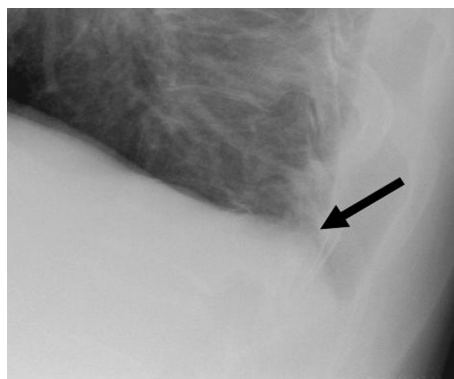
Chest CT (A) and lateral radiography (B) of a 39-year-old female patient.
